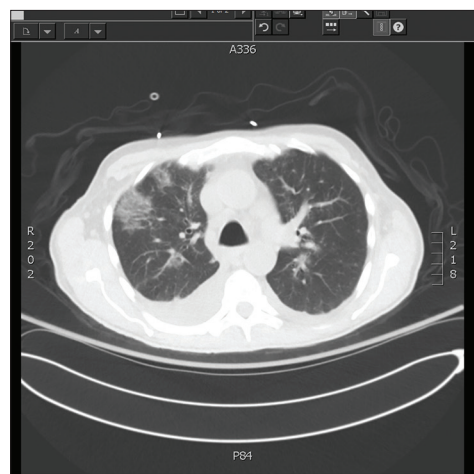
Computed tomography scan of the chest upon disseminated intravascular coagulation manifestation
